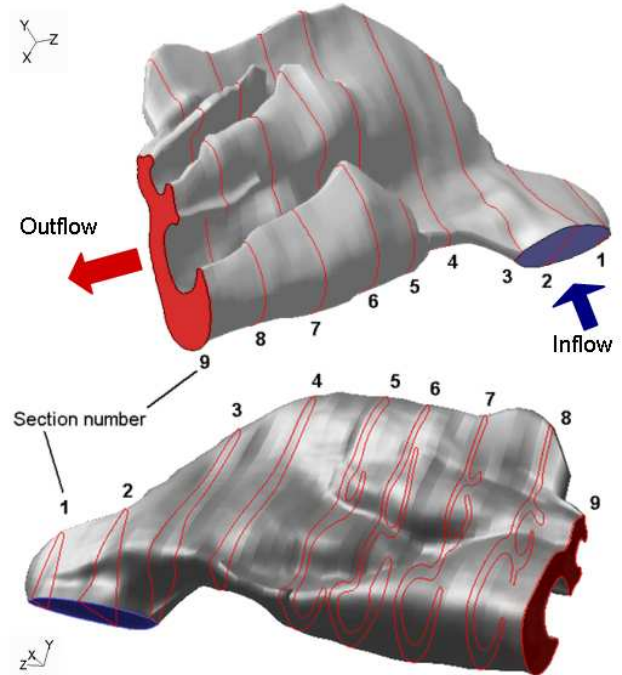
Computational domain is an anatomically corrected model of an adult nose built from CT slice data.
